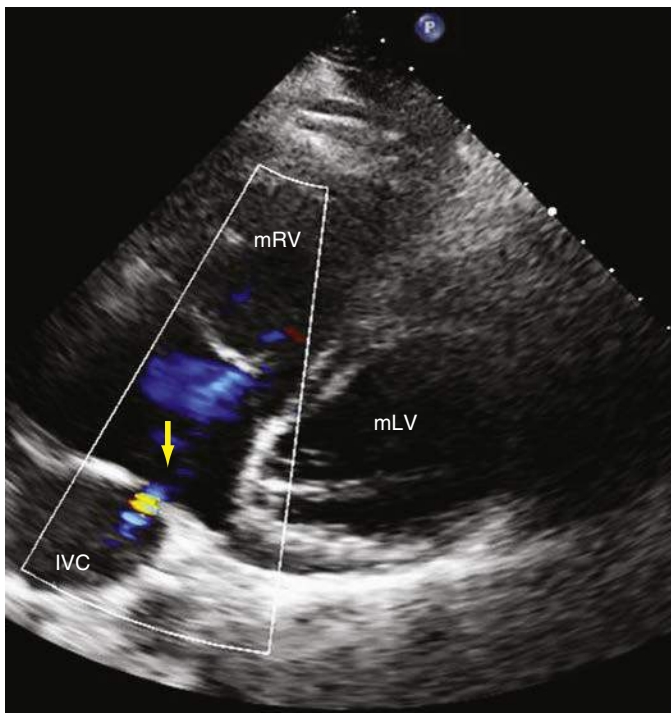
Two-dimensional (2D) color-flow image of transthoracic echocardiography (TTE) from a patient with transposition of great arteries (TGA) after Mustard repair showing IVC baffle leak (yellow arrow). IVC, Inferior vena cava; mLV, morphologic left ventricle; mRV, morphologic right ventricle.
